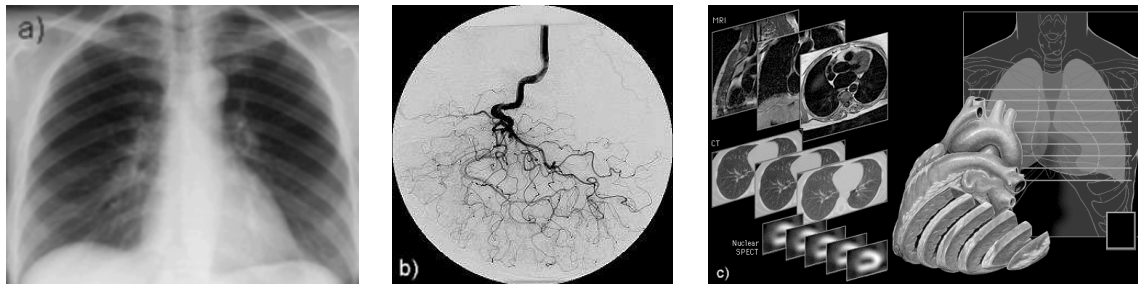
a) and b) X-ray radiography and Angiography. Two examples of projection techniques. Overlapping of structures are clearly appreciated. c) Tomographic scheme showing how anatomy is sliced.
